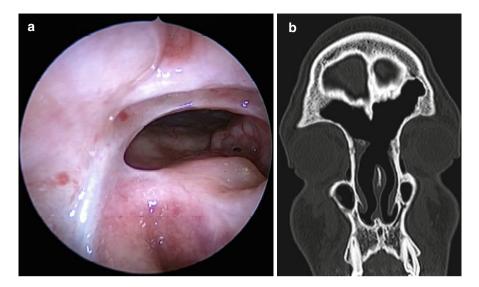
(a, b) Endoscopic view at 1-year demonstrates patent frontal neo-ostium after Lothrop procedure. Corresponding coronal bone window CT demonstrates excellent frontal aeration
